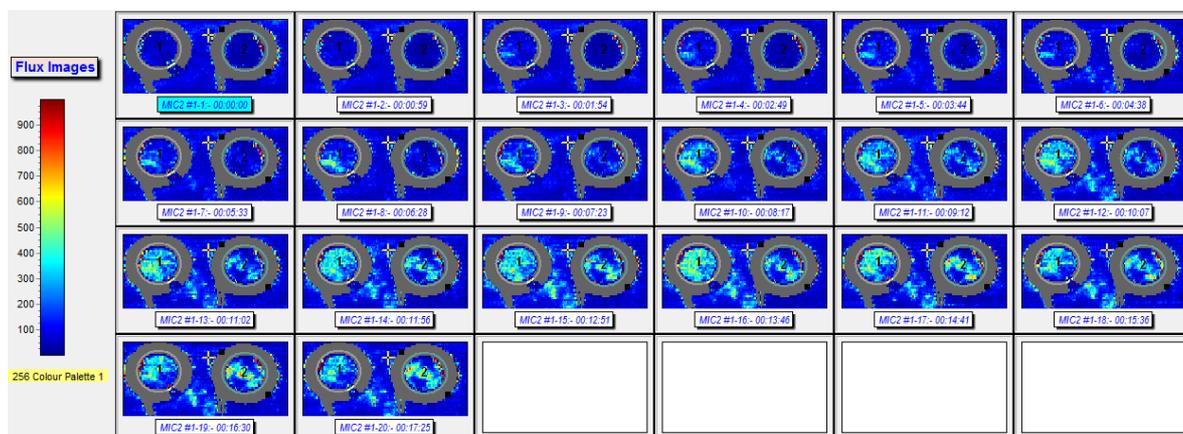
Flux images acquired with the moorLDI2-IR Laser Doppler Imager in young healthy man.
